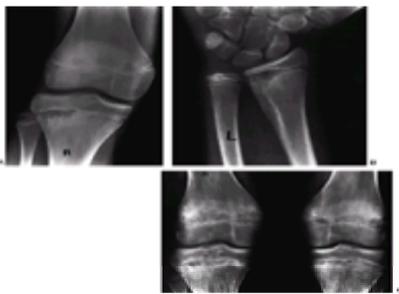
A 12-year-old girl presented with recurrent limp over a period of 18 months. She complained of pain in the right knee. Examination demonstrated tenderness about the right knee, but no other signs of inflammation. A: Radiograph of the right knee showed metaphyseal irregularity of the proximal tibia. B: Skeletal survey demonstrated additional similar lesions in the opposite knee, distal tibia, and radius. These lesions were asymptomatic. C: Radiographs 1 year later show diffuse metaphyseal changes of the distal femur and proximal tibia of both legs. No antibiotics were administered, and the symptoms resolved over the next several months.
